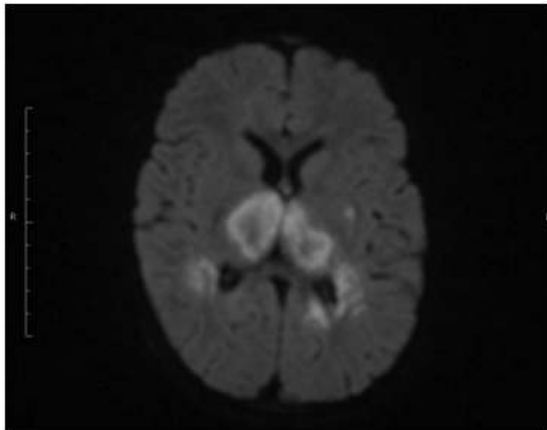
Restricted diffusion seen in bilateral thalami on DWI.
